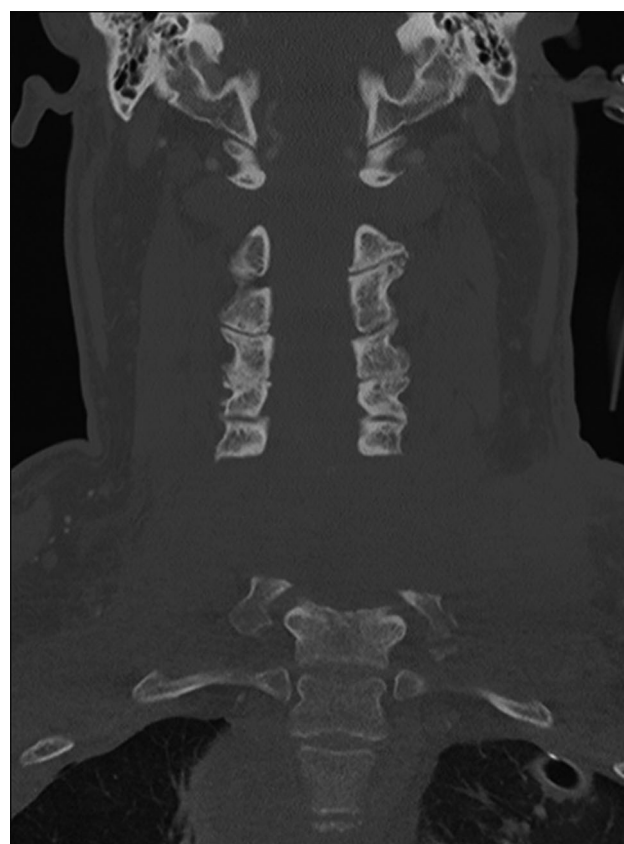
Coronal computed tomography scan of the cervical spine without contrast showing severe subaxial cervical distraction injury, C6 from C7, measuring 3.6 cm
